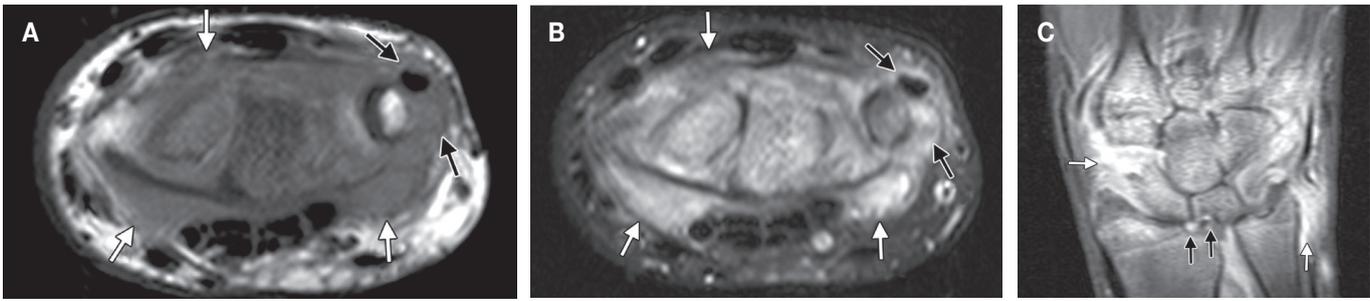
Synovitis in early RA of the wrist (9 months duration). Radiography revealed small erosions of the distal radius. Axial T1-w (a) and fat-suppressed T2-w (b) MR images show extensive synovitis at the dorsal and volar aspects of the wrist (white arrows), which has intermediate signal intensity in a and intermediate to high signal intensity in b. Black arrows indicate tenosynovitis of the extensor carpi ulnaris tendon. (c) Coronal gadolinium-enhanced fat-suppressed T1-w MR image shows marked enhancement of the wrist synovitis (white arrow at left). Note the diffuse bone marrow oedema, whose area of involvement includes two small erosions of the articular margin of the distal radius (black arrows). There is also enhancing tenosynovitis in the extensor tendon compartment (white arrow at right).
